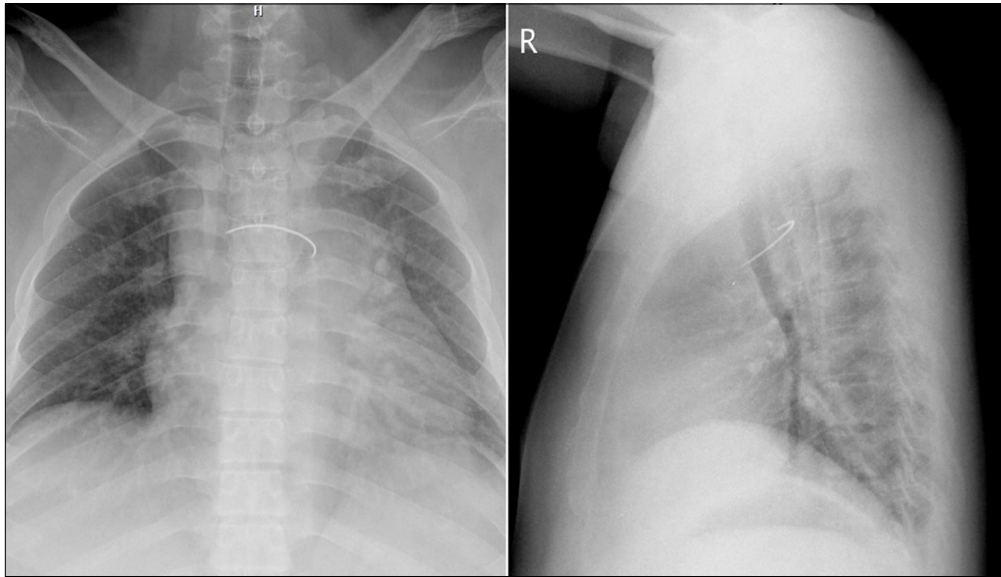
Chest radiograph showing a large semicircular metallic foreign body projected over the mid-thoracic region.
